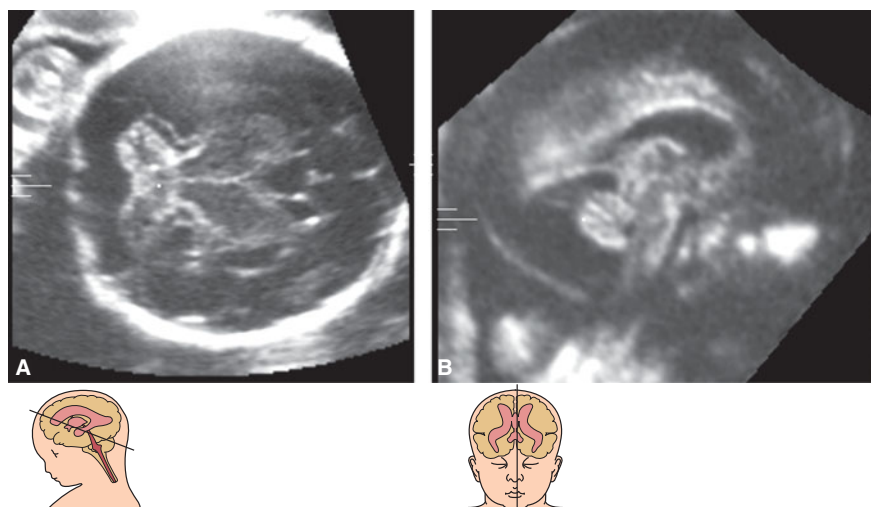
Megacisterna magna in a fetus with trisomy 18. The head appears round, the cavum septi pellucidi is enlarged, the vermis has an unusual appearance, and multiple extracranial anomalies were present. (Reproduced, with permission, from *Atlas of Obstetric Ultrasound*, 2009. The Global Library of Women's Medicine, www.glowm.com.)
